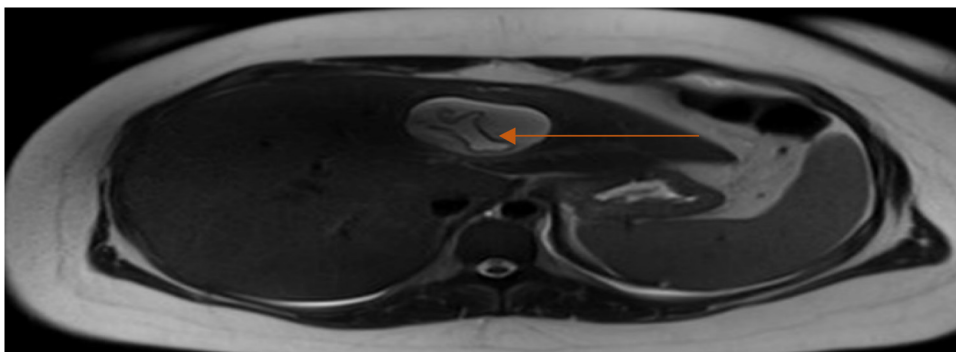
MRI Liver showing water lily sign in the left lobe of the liver.
